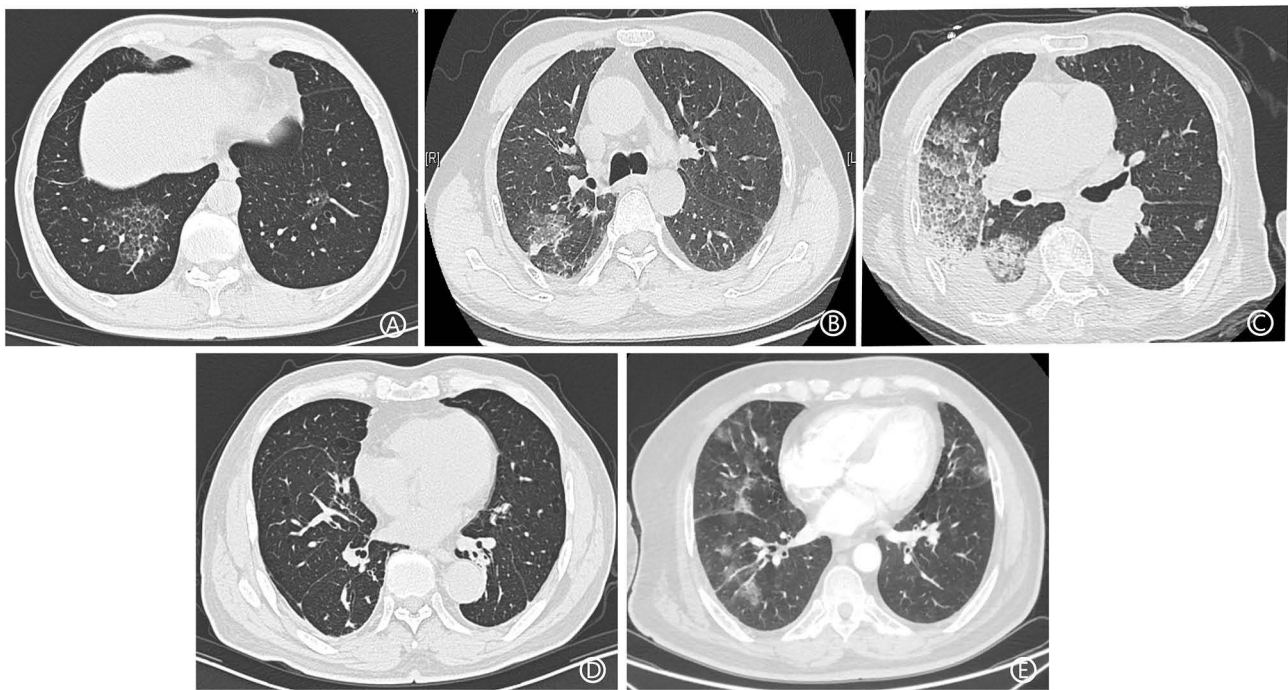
Chest CT images of the five patients.
